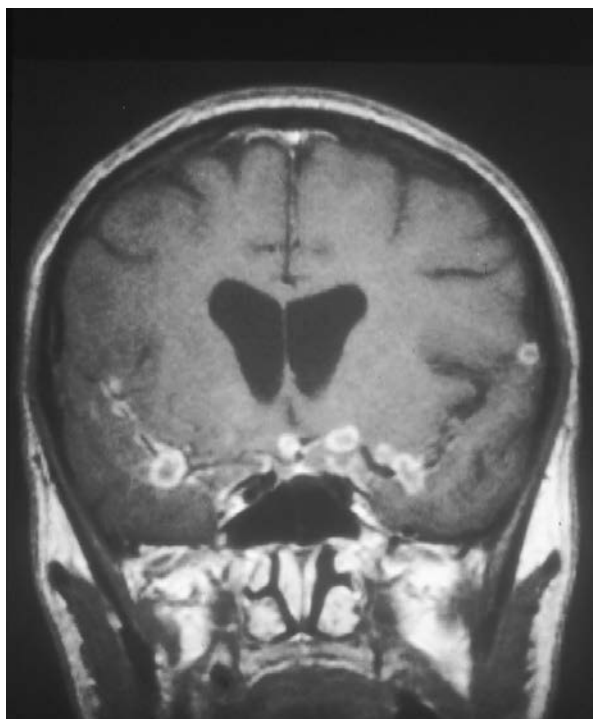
Coronal T_1 -weighted contrast-enhanced MRI scan in TB meningitis. Numerous basal tuberculous foci are identified. (Courtesy of Dr R.T. Johnson.)
